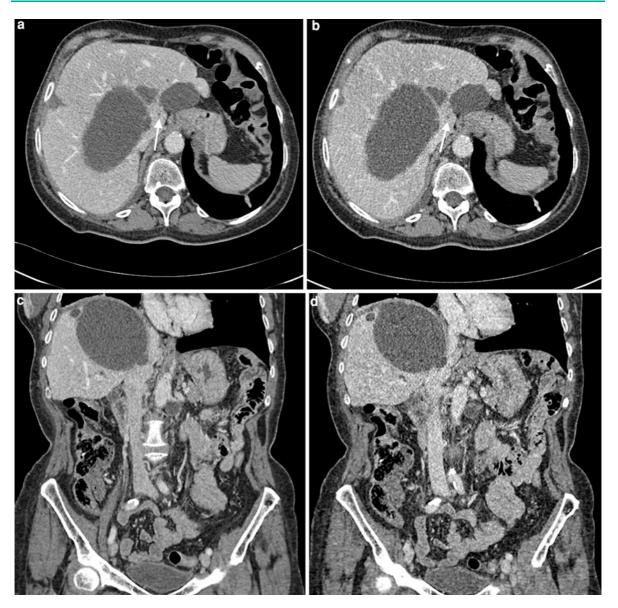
Transverse (a, b) and coronal (c, d) IV enhanced CT images obtained in an 81-year-old-woman with a BMI of 29.3 kg/m². A first acquisition (a, c) has been performed at standard-dose CT (120 kVp, 154 effective mAs with AEC; CTDIvol: 11.8 mGy; DLP: 523 mGy cm) directly followed by a low-dose CT with the same Z-coverage (b, d) with reduced tube voltage and slightly reduced tube current (100 kVp, 143
